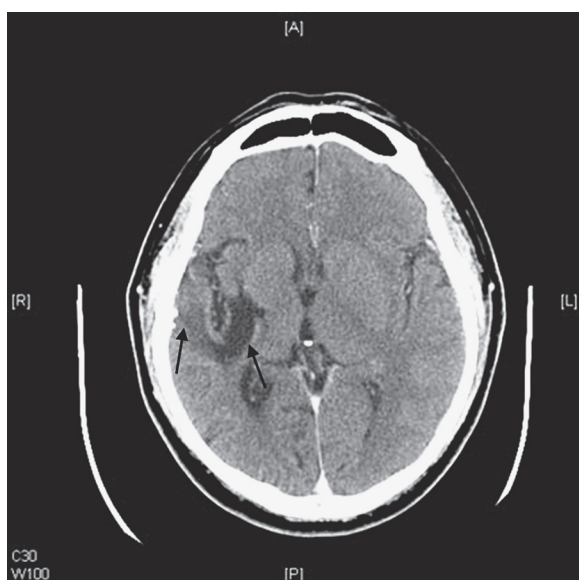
CT image from a representative slice. Two encephalomalacia lesions can be observed at the right basal ganglia and right temporal lobe (indicated by black arrows).
